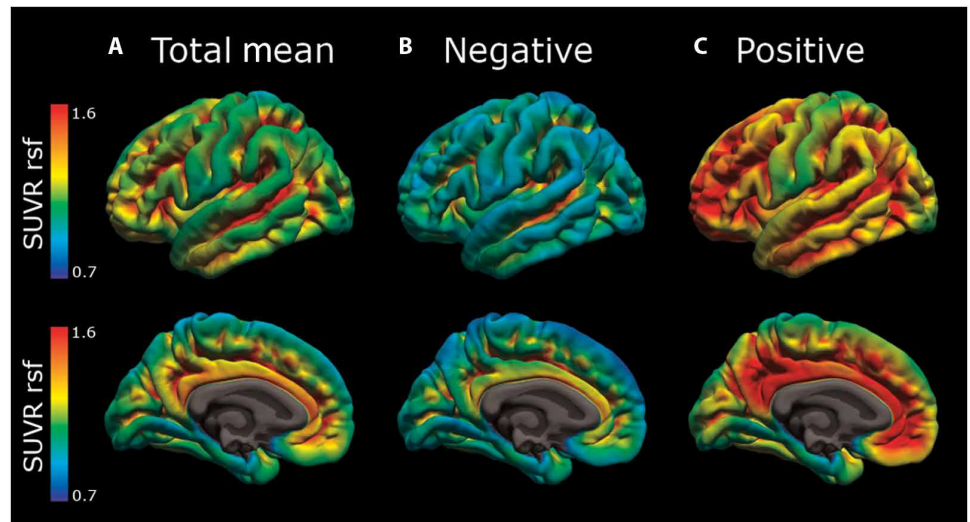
Mean amyloid pathology for the 38 participants with PET imaging. Mean AV-45 amyloid pathology in (A) all, (B) amyloid-negative, and (C) amyloid-positive subjects as measured in SUVR units after partial volume correction using a regional spread function (rsf).
